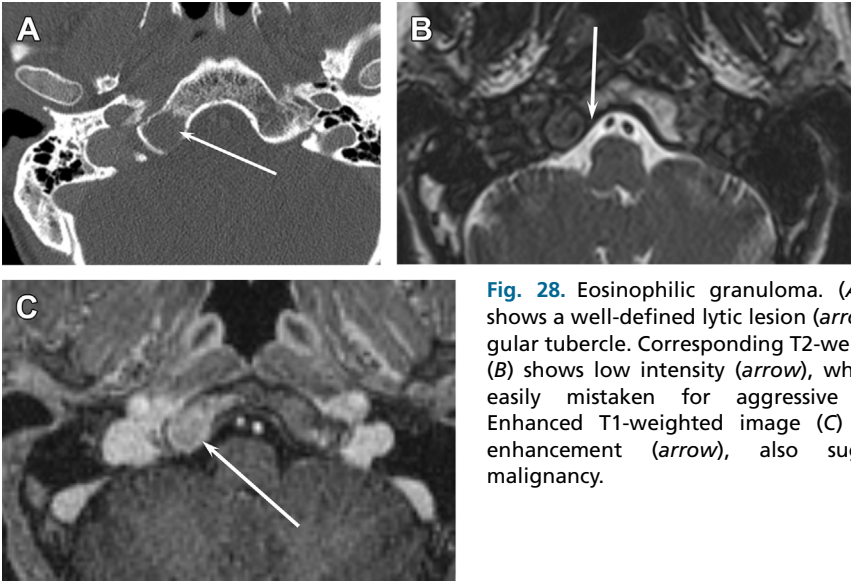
Eosinophilic granuloma. (A) CT image shows a well-defined lytic lesion (*arrow*) in the jugular tubercle. Corresponding T2-weighted image (B) shows low intensity (*arrow*), which could be easily mistaken for aggressive malignancy. Enhanced T1-weighted image (C) shows brisk enhancement (*arrow*), also suggestive of malignancy.
